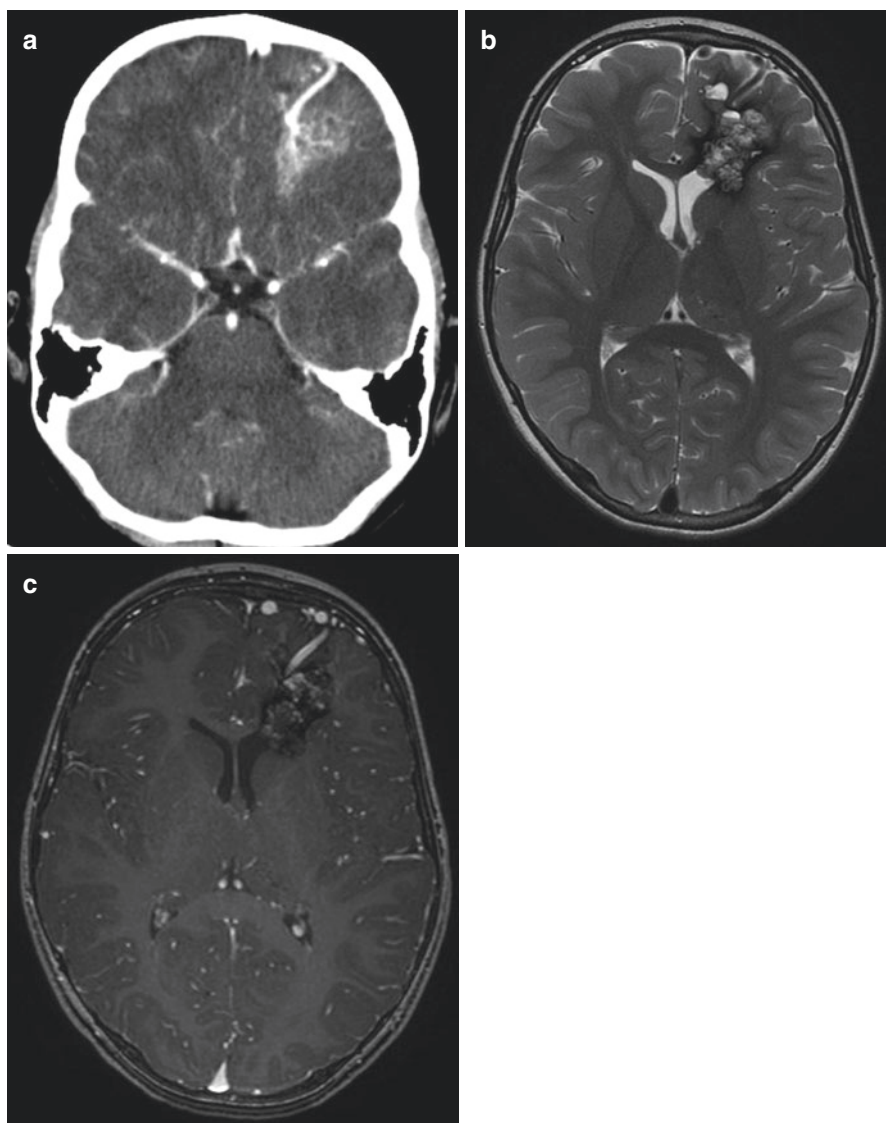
Axial CT (a), axial T2w (b), axial T1w post contrast MRI (c) demonstrate a large cavernoma in the left frontal white matter associated with a DVA draining in the superficial cortical vein with a caput medusae intimately related to a cavernoma
